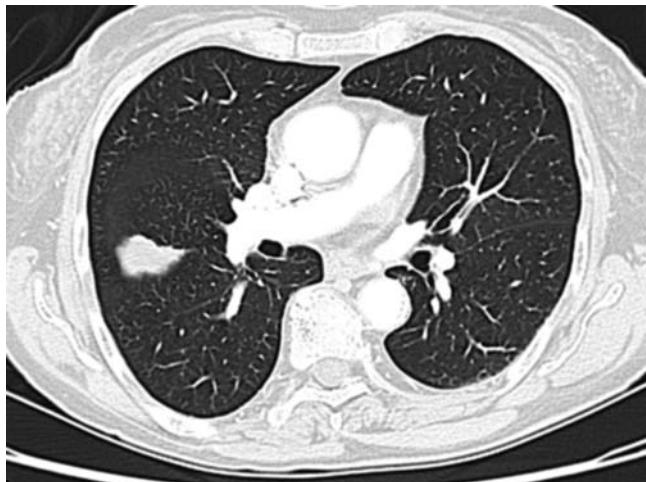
CT of chest showing a well-defined irregular density in the right middle lobe. Biopsy showed a metastatic leiomyosarcoma.
